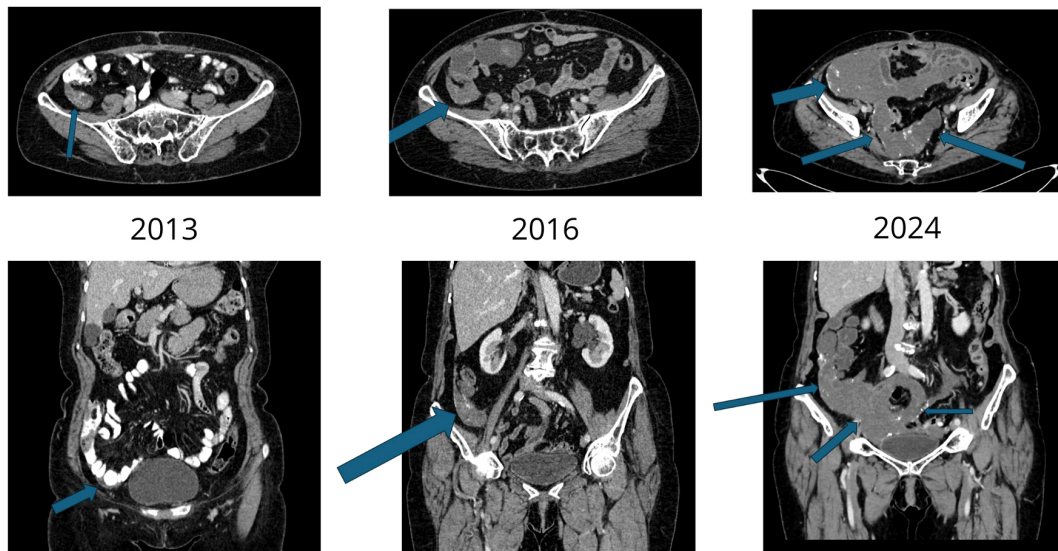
CT scans of patient's ovarian lesions in years 2013, 2016 and 2024. Blue arrows pointing at tumor mass found on the CT scans.
